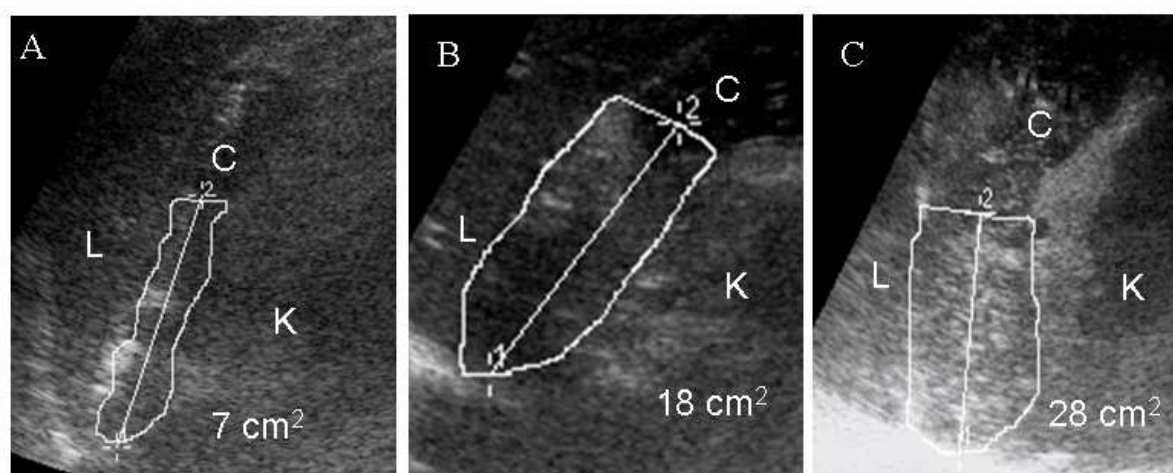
Ultrasonograms of area measurements of the proximal stomach. The 7 cm line is drawn from the fundus towards the corpus. The gastric cavity is outlined by the curved line and the measured area within the curved line is used as the area of the proximal stomach. The proximal area during fasting is shown in a healthy individual (panel A) and in a patient with FD (panel B). Panel C shows the proximal area at 1 min postprandially in a healthy individual. L= liver. C= corpus. K= left kidney.
